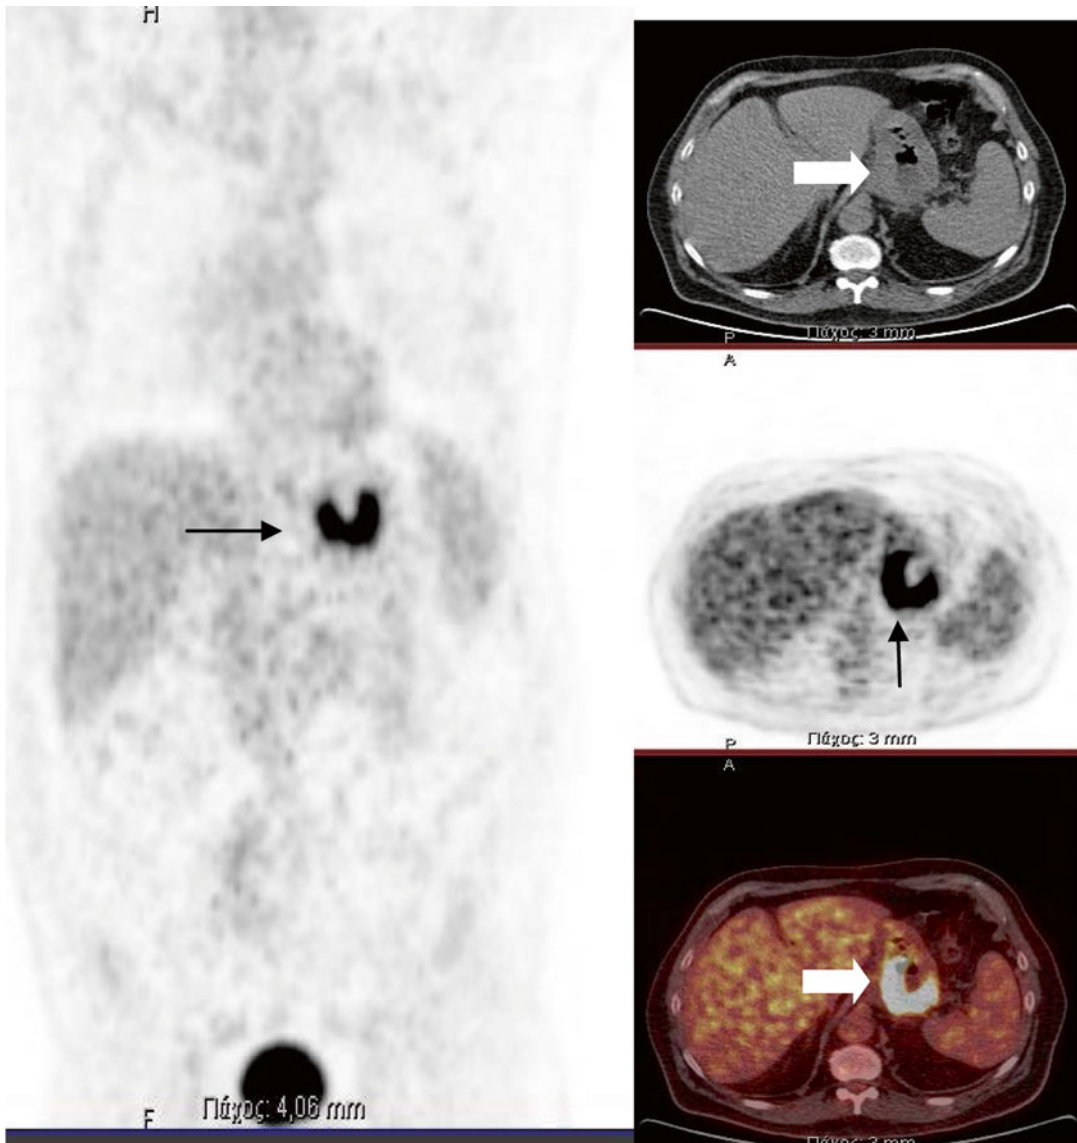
A 67-year-old male with DLBCL. Initial staging evaluation with PET/CT (coronal PET images (*left*) and transverse CT, PET, and fused images (*right*)) demonstrates
